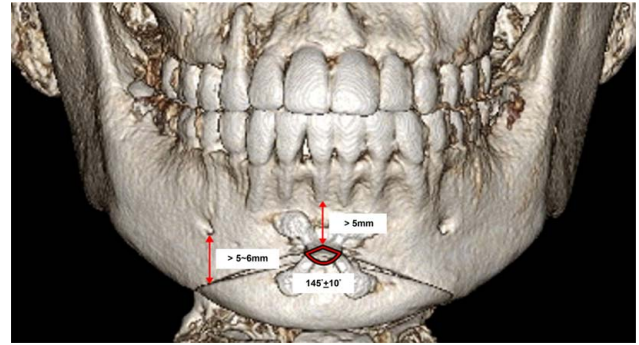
Three-dimensional CT image after inverted V osteotomy. The upper osteotomy lines (vertex of inverted V) in the submental region were positioned ~5 mm below the root apices of the lower anterior teeth and maintained a lateral distance of 5 to 6 mm from the mental foramen. The angle of the vertex is usually maintained at $145^\circ \pm 10$. Because the direction of the 2 lines of the inverted V osteotomy can be altered based on a patient's chin anatomy, the amount of midline deviation and chin asymmetry is reduced.
